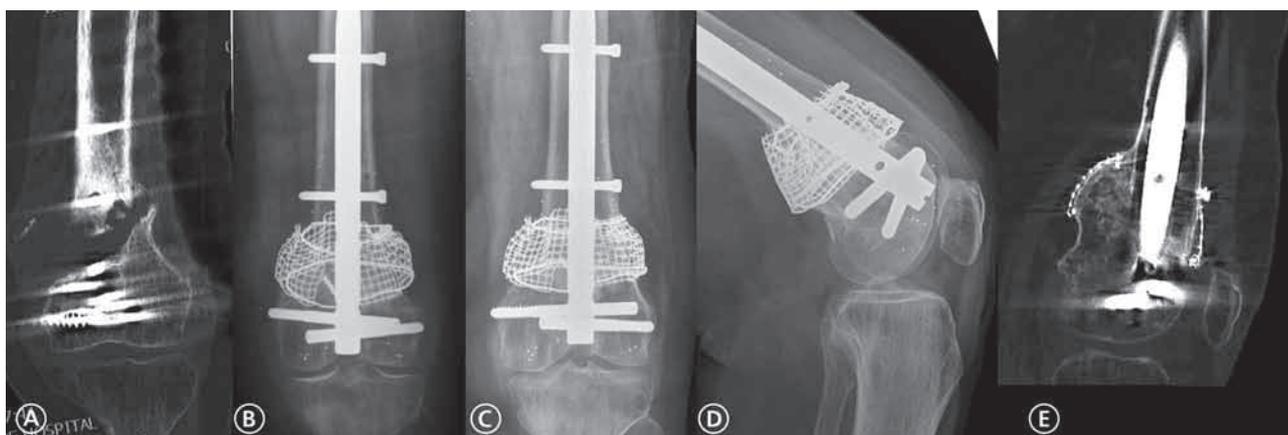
Sequential radiographs and CT scans of the left distal femur of a 74-year-old female whose femoral non-union and 3 cm metaphyseal distal femoral defect were treated with impaction grafting (Case 2). A) Coronal CT reconstruction through the non-union. B) Immediate post-reconstruction AP radiograph. C) and D) Two year post-reconstruction AP and lateral radiographs demonstrating maintenance of reduction/lengthening. E) Sagittal CT reconstruction through the nail two years after reconstruction. Note the graft remodeling and integration. Note that this process, as expected, is not uniform throughout the grafted area.
